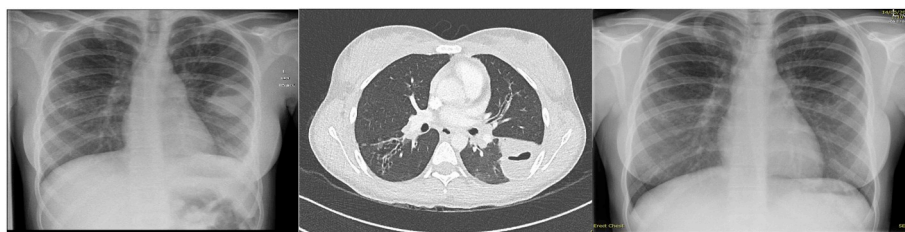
a (left): Chest Radiograph on Admission showing 4.5cm opacification in the left middle zone containing air fluid level. b (middle): Chest CT on day 1 of admission showing a 5cm lung abscess in the superior aspect of the left lower lobe. c (right) Chest radiograph six weeks later showing resolution of pulmonary abscess.
